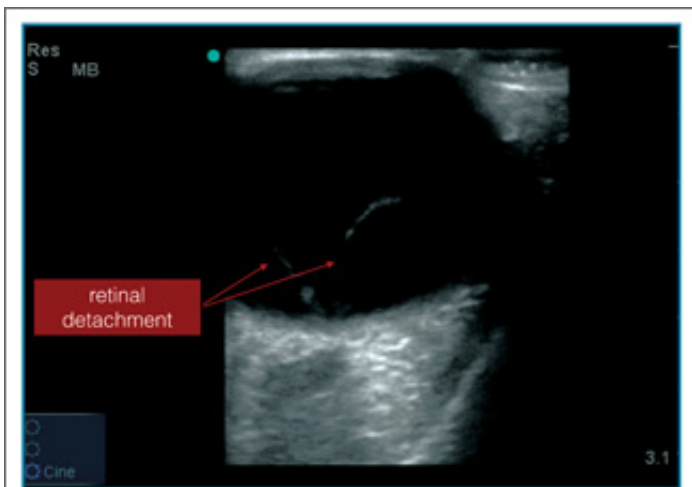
Ocular ultrasound showing a complete retinal detachment, with a V-shaped appearance of retinal membrane.
